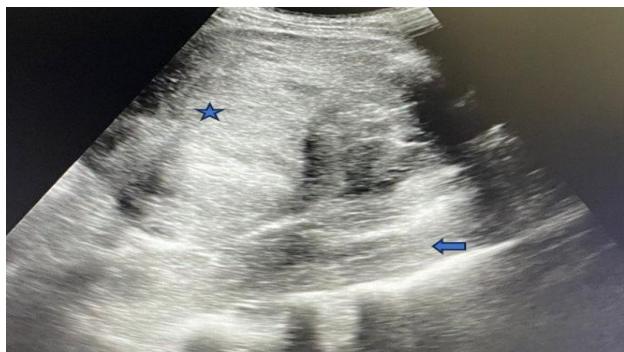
Ultrasound of the abdomen reveals a large heterogeneously hypoechoic mass lesion anterior to the left psoas muscle.
